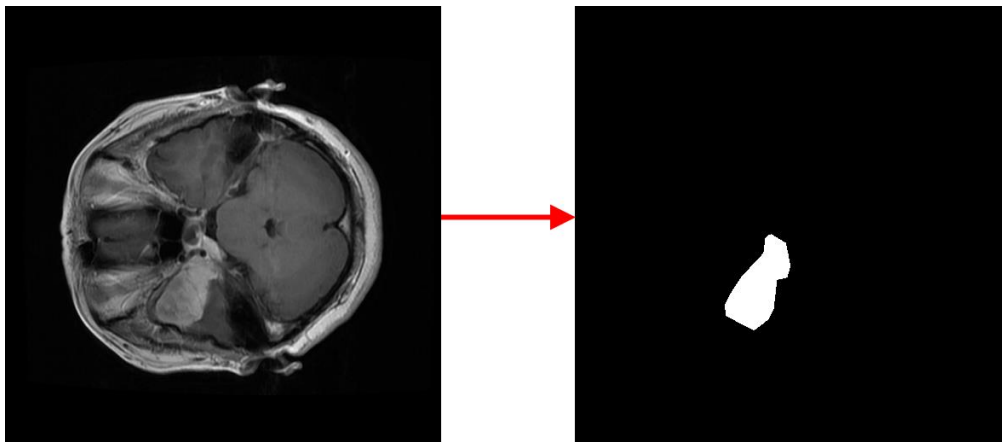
Example of manual segmentation of MRI image
